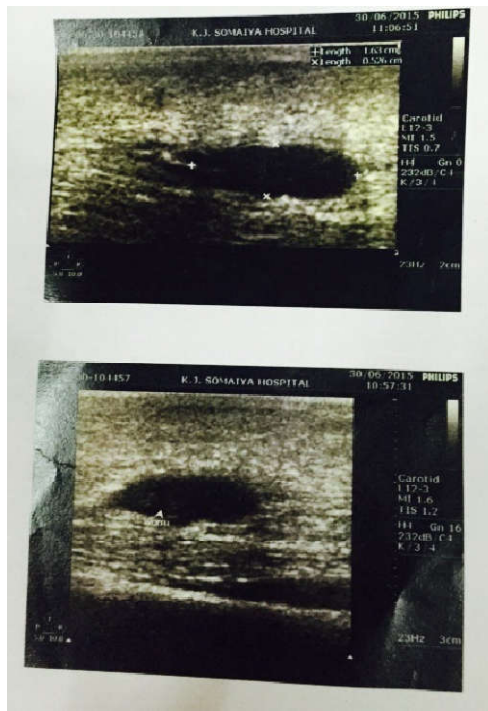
Ultrasonographic appearance of intramuscular cysticercosis
